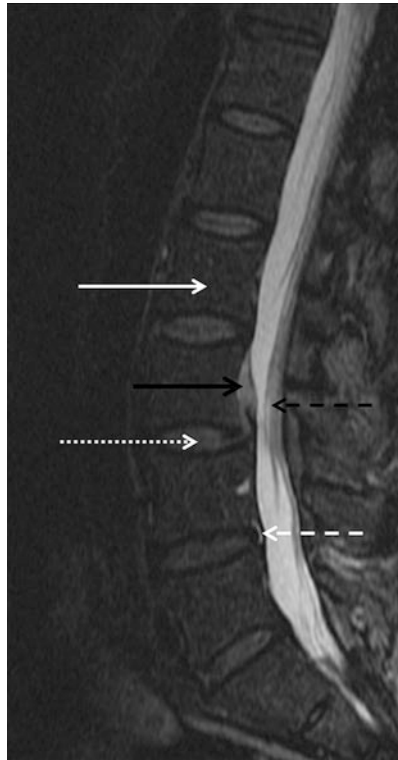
Sagittal fluid-sensitive sequence (STIR, *short tau inversion recovery*) MR image of the lumbar spine demonstrates the utility of fluid sensitive sequences in depicting disc pathology. The bright signal intensity of fat is nulled, such as in the marrow (*solid white arrow*) resulting in only fluid signal to be hyperintense, as in the cerebrospinal fluid and nucleus pulposus of the intervertebral disc (*dotted white arrow*). Note the hyperintense disc
